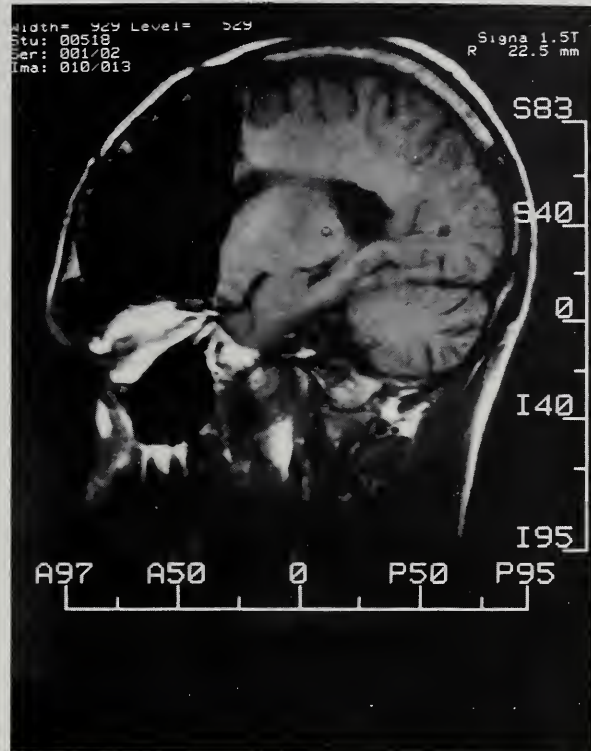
MRI four years after right frontal lobectomy for intractable major motor and minor seizures. Today only some very brief (seconds) minor episodes. On anticonvulsants.
